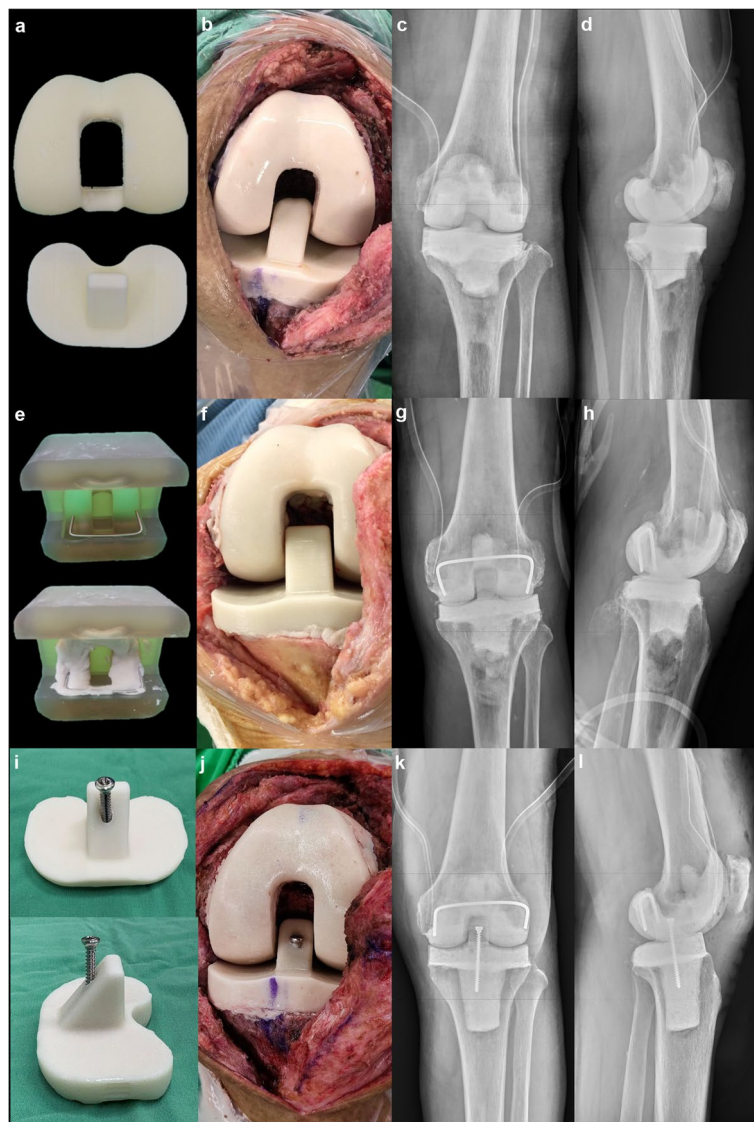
a-d. The non-reinforced posterior-stabilized spacer. a The spacer after fabrication; b the knee joint with the spacer implanted; c anteroposterior and (d) lateral radiographs of the postoperative knee showing the spacer in situ. e-h. The cam-reinforced alone posterior-stabilized spacer. e A bended saddle-like 3.0-mm Kirschner wire within the cam and bilateral posterior condyles; f knee joint with the spacer implanted; g anteroposterior and (h) lateral radiographs of the postoperative knee showing the spacer in situ. i-l. The post- and cam-reinforced posterior-stabilized spacer. i A 3.5 mm screw with adequate length passed through the tibial post, spacer, and cement stem (j) knee joint with the spacer implanted; k anteroposterior and (l) lateral radiographs of the postoperative knee showing the spacer in situ
